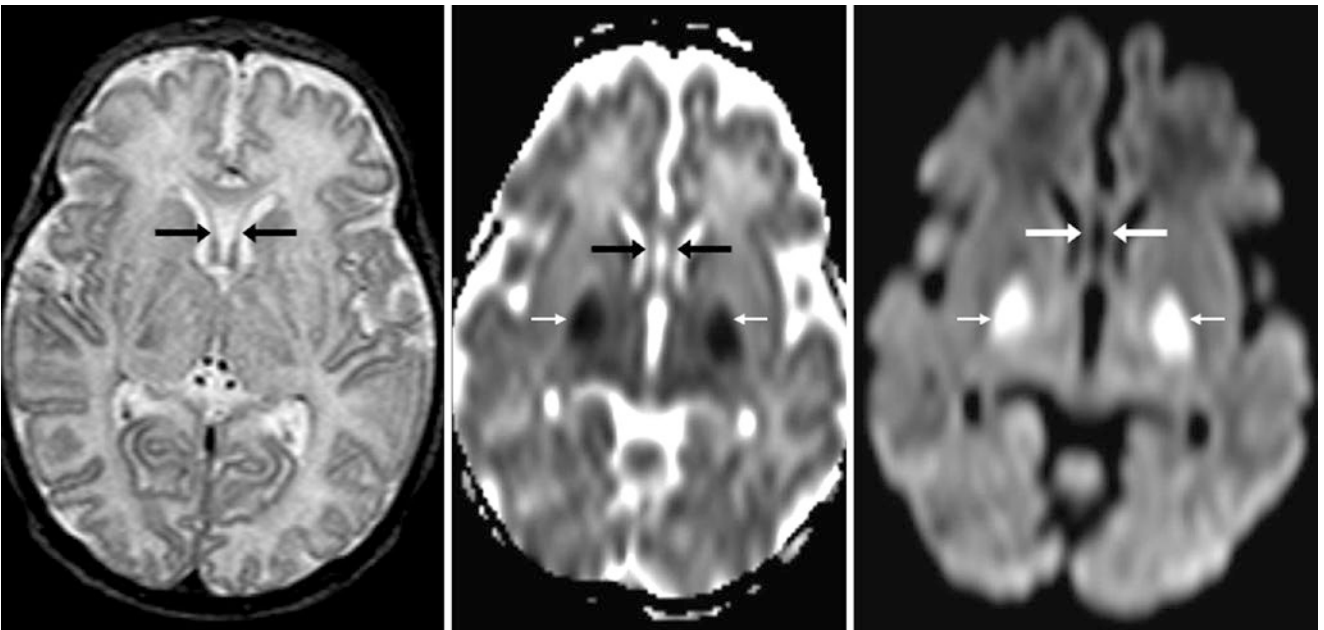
A 1-week-old term infant with severe HII who had an incidental tiny CSP (*arrows*). MRI demonstrates abnormal signal (*tiny arrows*) in the putamina and globi pallidi on axial T2WI (*left*), ADC map (*middle*), and DWI (*right*)
